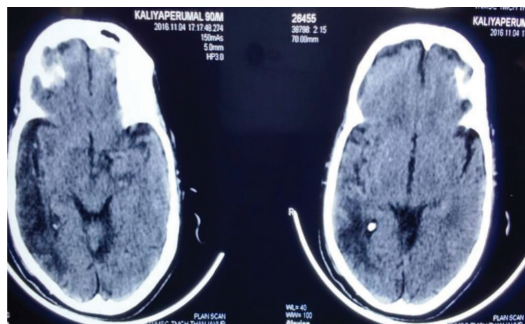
A 65 year old male presented with 3 episodes of generalised tonic clonic seizures in last 1 month. The seizures occurred during night time. During episodes of seizures patient had frothing of mouth and there was one episode of tongue bite. After the seizures he remained in altered sensorium for 10-15 minutes. For these complaints he was brought to us. A CT scan was done which showed infarct in right MCA territory. He was given phenytoin sodium to which he responded and later there were no further episodes of seizures
